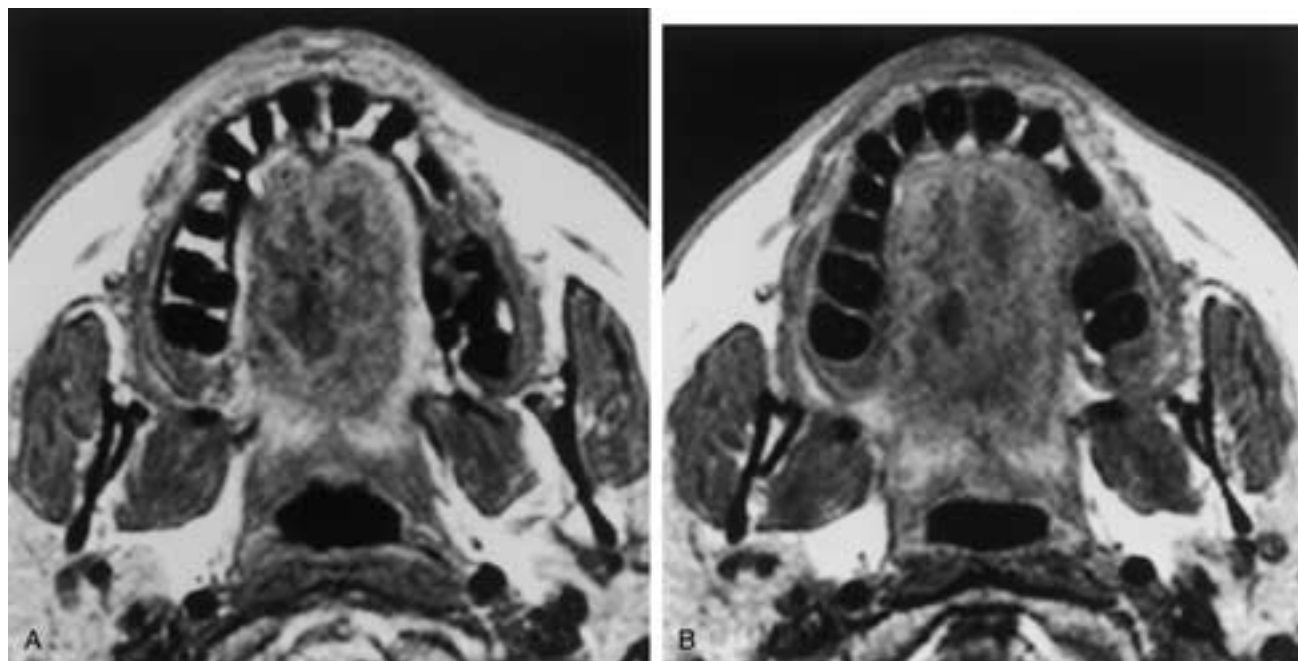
Diffuse lymphangioma of the tongue. A and B, Axial T1-weighted MR images demonstrate poorly defined multiple areas of hypointensity bilaterally within the tongue.
